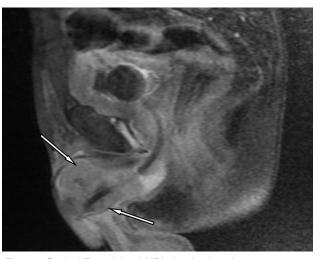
Sagittal T1 weighted MRI showing hypointense mass at the base of penis with loss of fat plane
